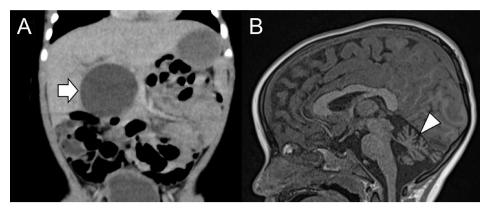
Radiographic features in the abdomen and brain. (A) A coronal image of abdominal magnetic resonance imaging at 3 months of age showed a dilated bile duct (an arrow). (B) A sagittal image of cerebral magnetic resonance imaging at 3 years and 8 months of age showed cerebellar atrophy (an arrowhead).
